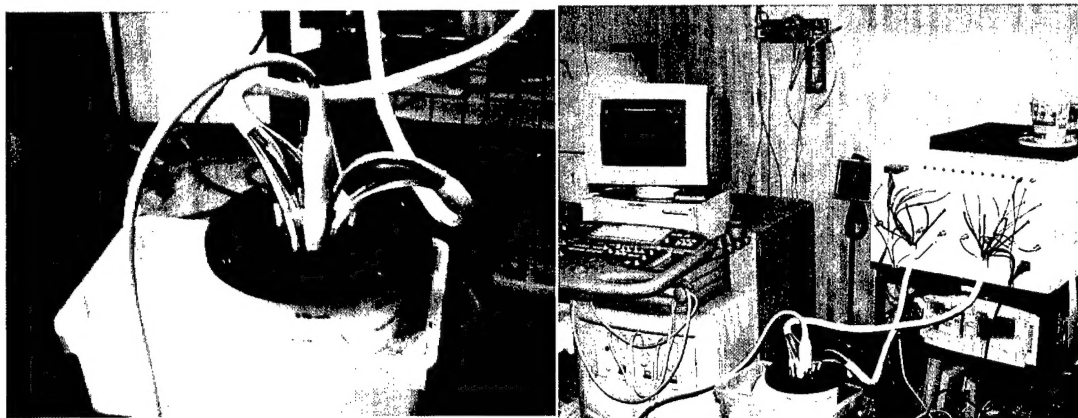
(a). Our combined probe with NIR sensors deployed at the periphery and a 1-D commercial ultrasound array located in the middle. (b). Commercial ultrasound scanner (left), our NIR system (right) and the combined probe (middle).
